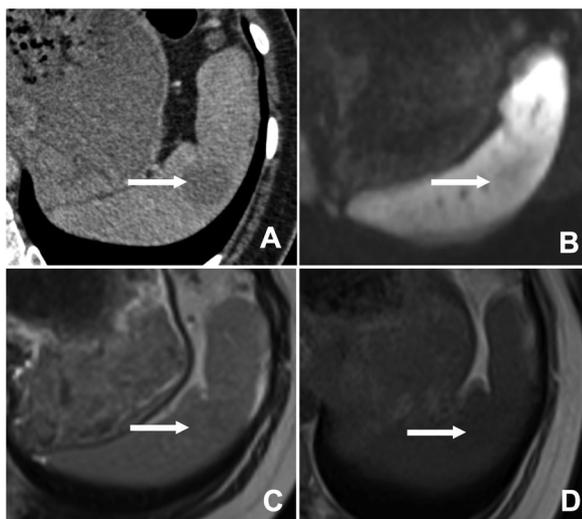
39-year-old man with peritoneal carcinomatosis from colic adenocarcinoma and splenic involvement. A solid intrasplenic lesion (arrow) was visualized on CT image by two independent readers (A) whereas no lesion was visible on diffusion-weighted MRI (B), T2-weighted MRI (C) or T1-weighted MRI (D) by the same two independent readers. PC was confirmed at pathological examination.
